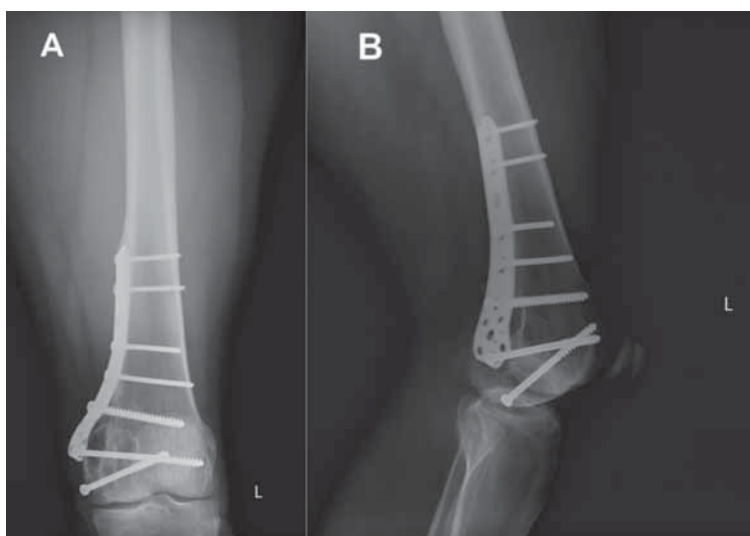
Final follow-up radiographs of the left knee three years after surgery: (A) anteroposterior view; (B) lateral view.
